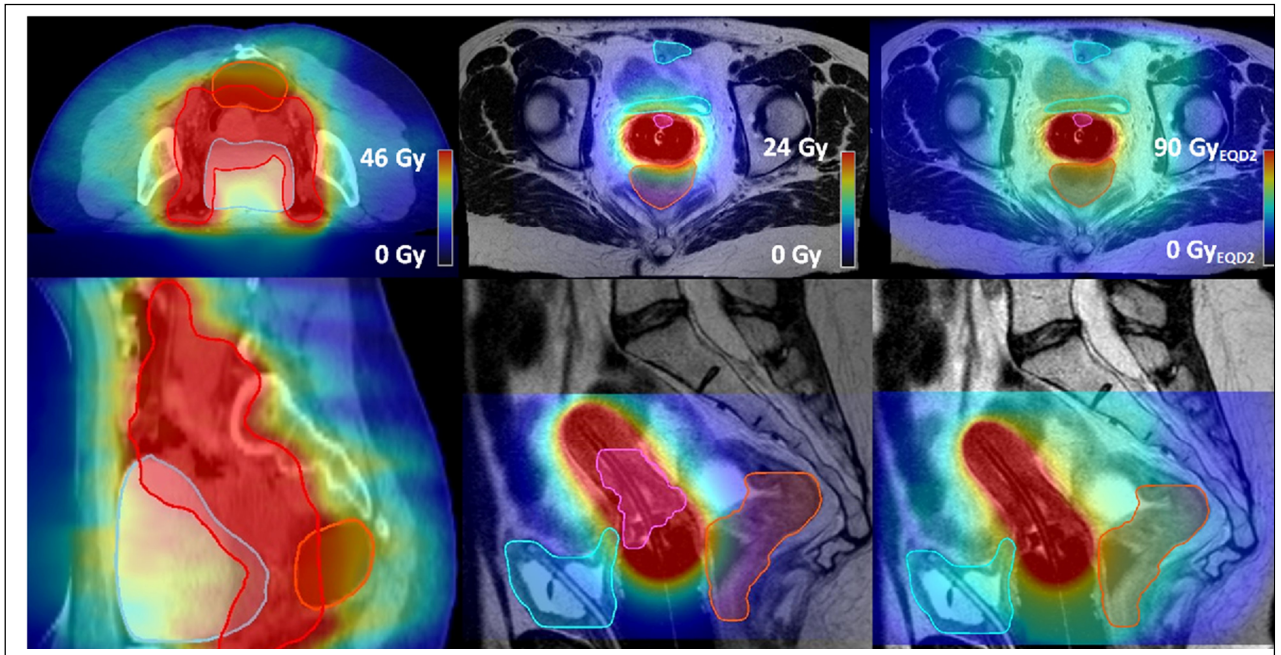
Dose accumulation of external beam radiotherapy and brachytherapy in cervical cancer. Axial (top row) and sagittal (bottom row) on CT (left column) and MRI (middle and right columns). A colour wash of the planned VMAT/BT dose (middle column) and the accumulated dose (right column) from EBRT and BT is overlaid. The EBRT dose is not uniform at the bladder/rectal walls (blue/orange) closest to the target.
